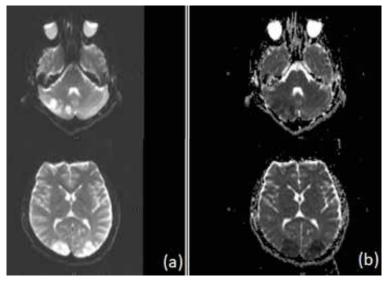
(a) MRI brain diffusion-weighted imaging (DWI) sequence demonstrating multiple hyper intense signals in right cerebellar hemisphere and bilateral occipital lobes. (b) Apparent diffusion coefficient (ADC) sequence with corresponding area of low intensity consistent with an acute infarct.
